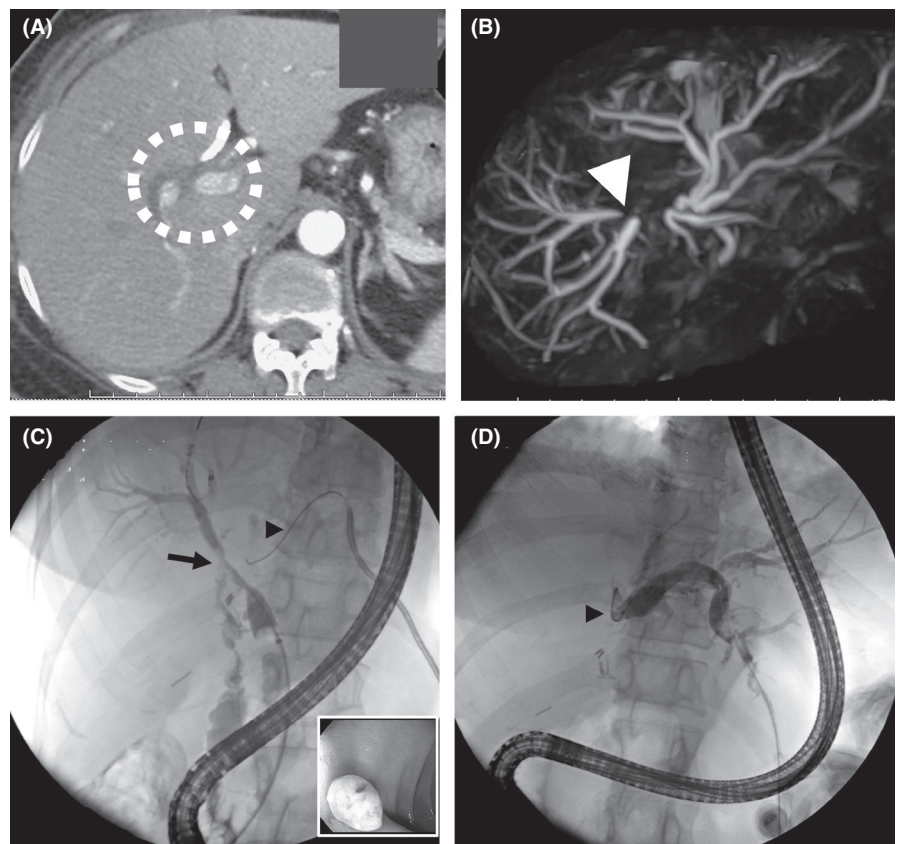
Preoperative imaging evaluation. (A) Computed tomography of the liver showed injury to the right hepatic artery (circle) with distal reconstitution. (B) Magnetic resonance cholangiography showed E4 injury with noncommunication of the right anterior and posterior ducts (white arrow). (C) Endoscopic retrograde cholangiography with percutaneous cholangiography (PTC) revealed a bilioenteric fistula extending to the duodenum (black arrow) and a wire in the left hepatic duct (LHD) (arrowhead). (D) PTC showed noncommunication of the LHD (arrowhead) with the right hepatic duct and an E4 injury
